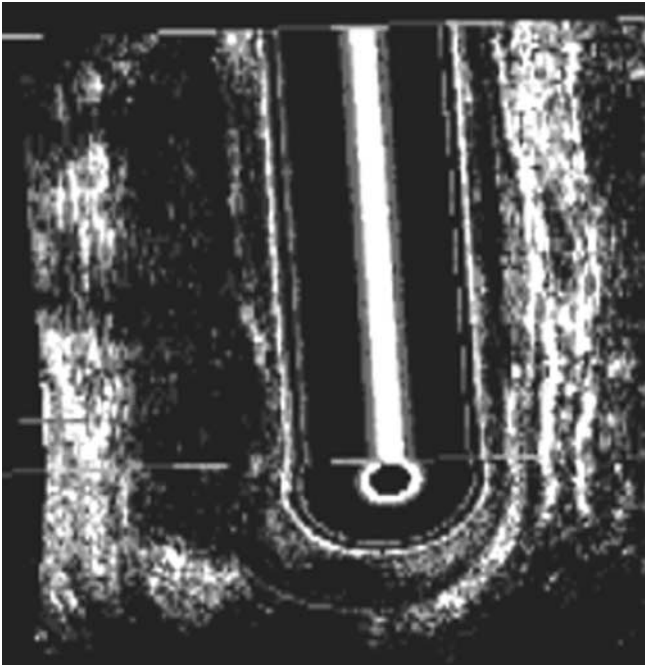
3D endosonogram of an anal carcinoma. Longitudinal view. The margin of infiltration is clearly seen
